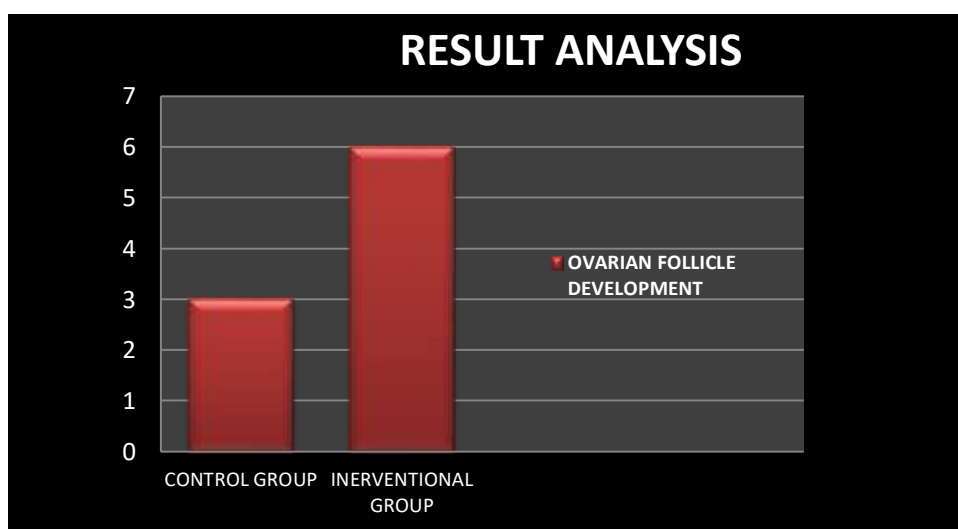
the ovarian follicle development of all 20 subjects in both groups who were monitored through ultrasound imaging.
